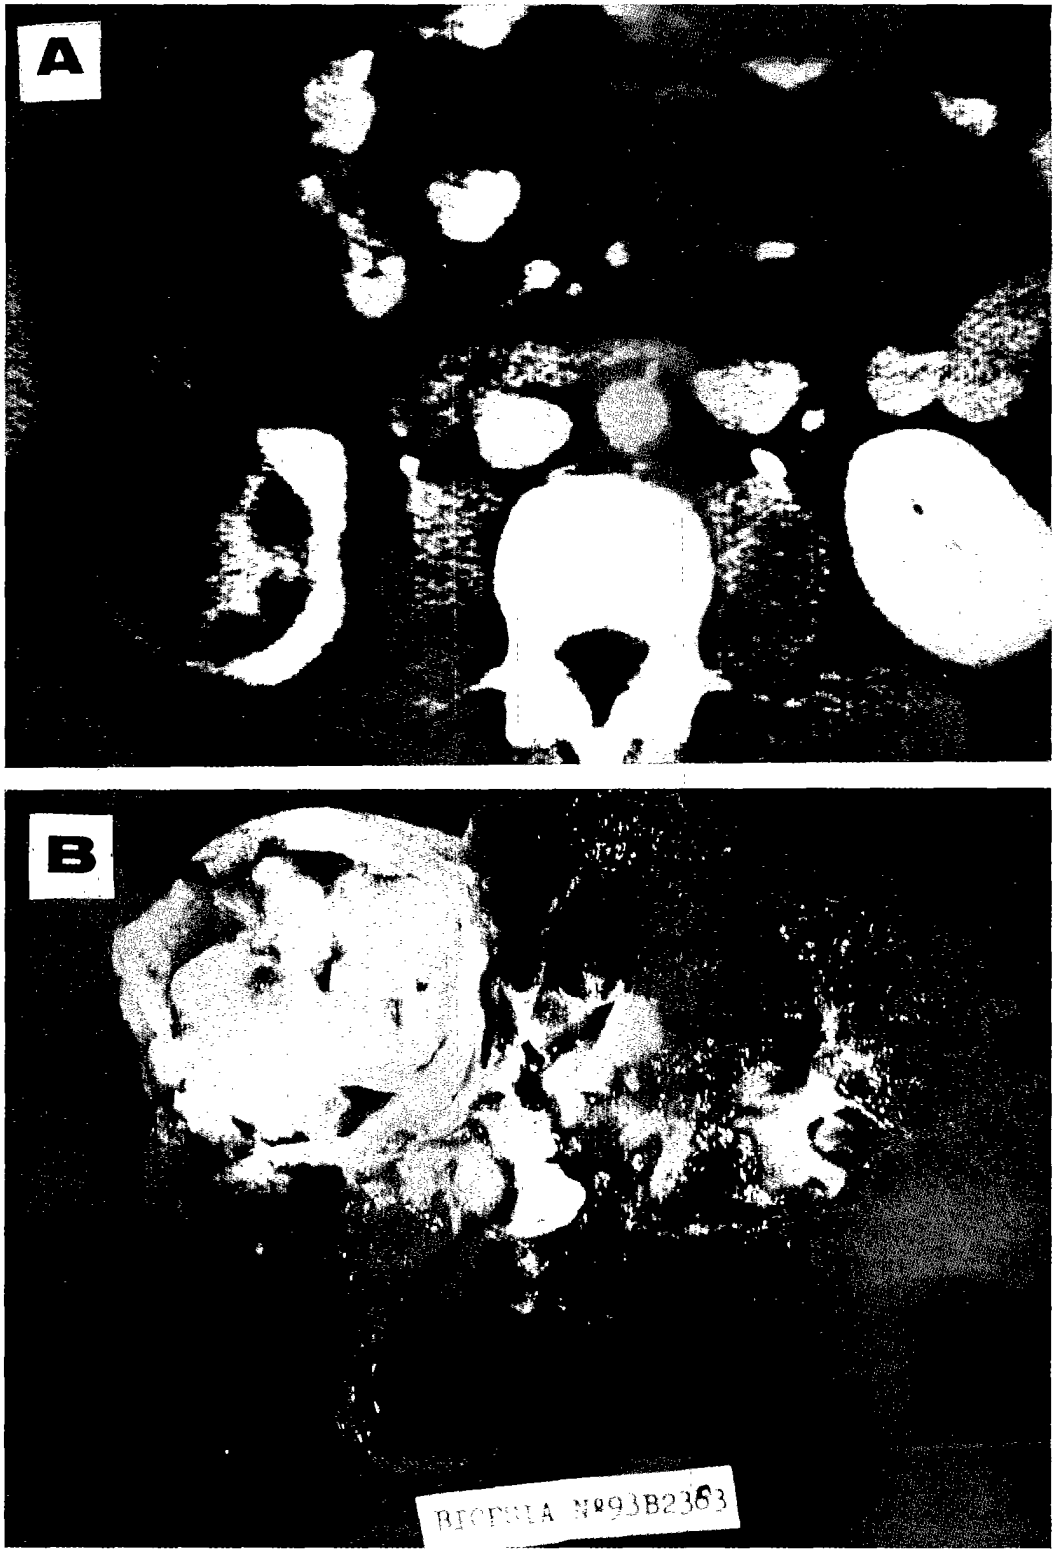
(A) Computed tomography: solid-cystic mass in the right kidney. (B) Section of the right kidney showing a polypoid intracystic mass without continuity with renal pelvis.
